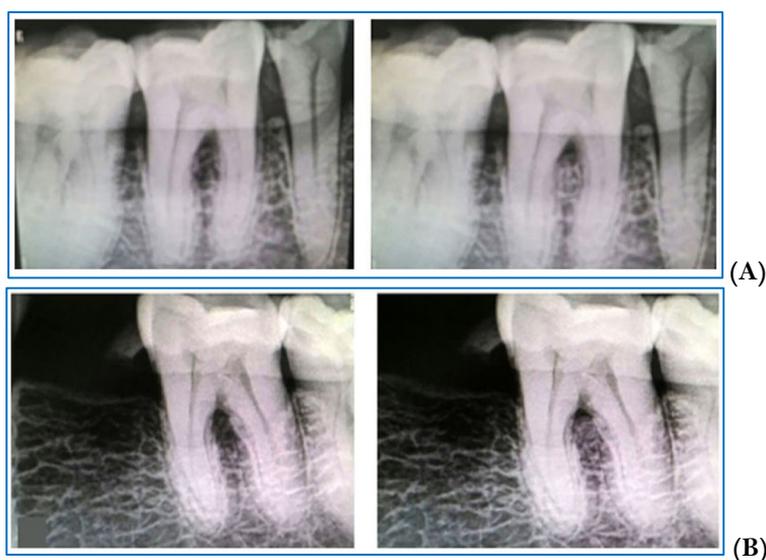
(A) Pre-operative and post-operative radiographs at control site; (B) Pre-operative and post-operative radiographs at test site.
